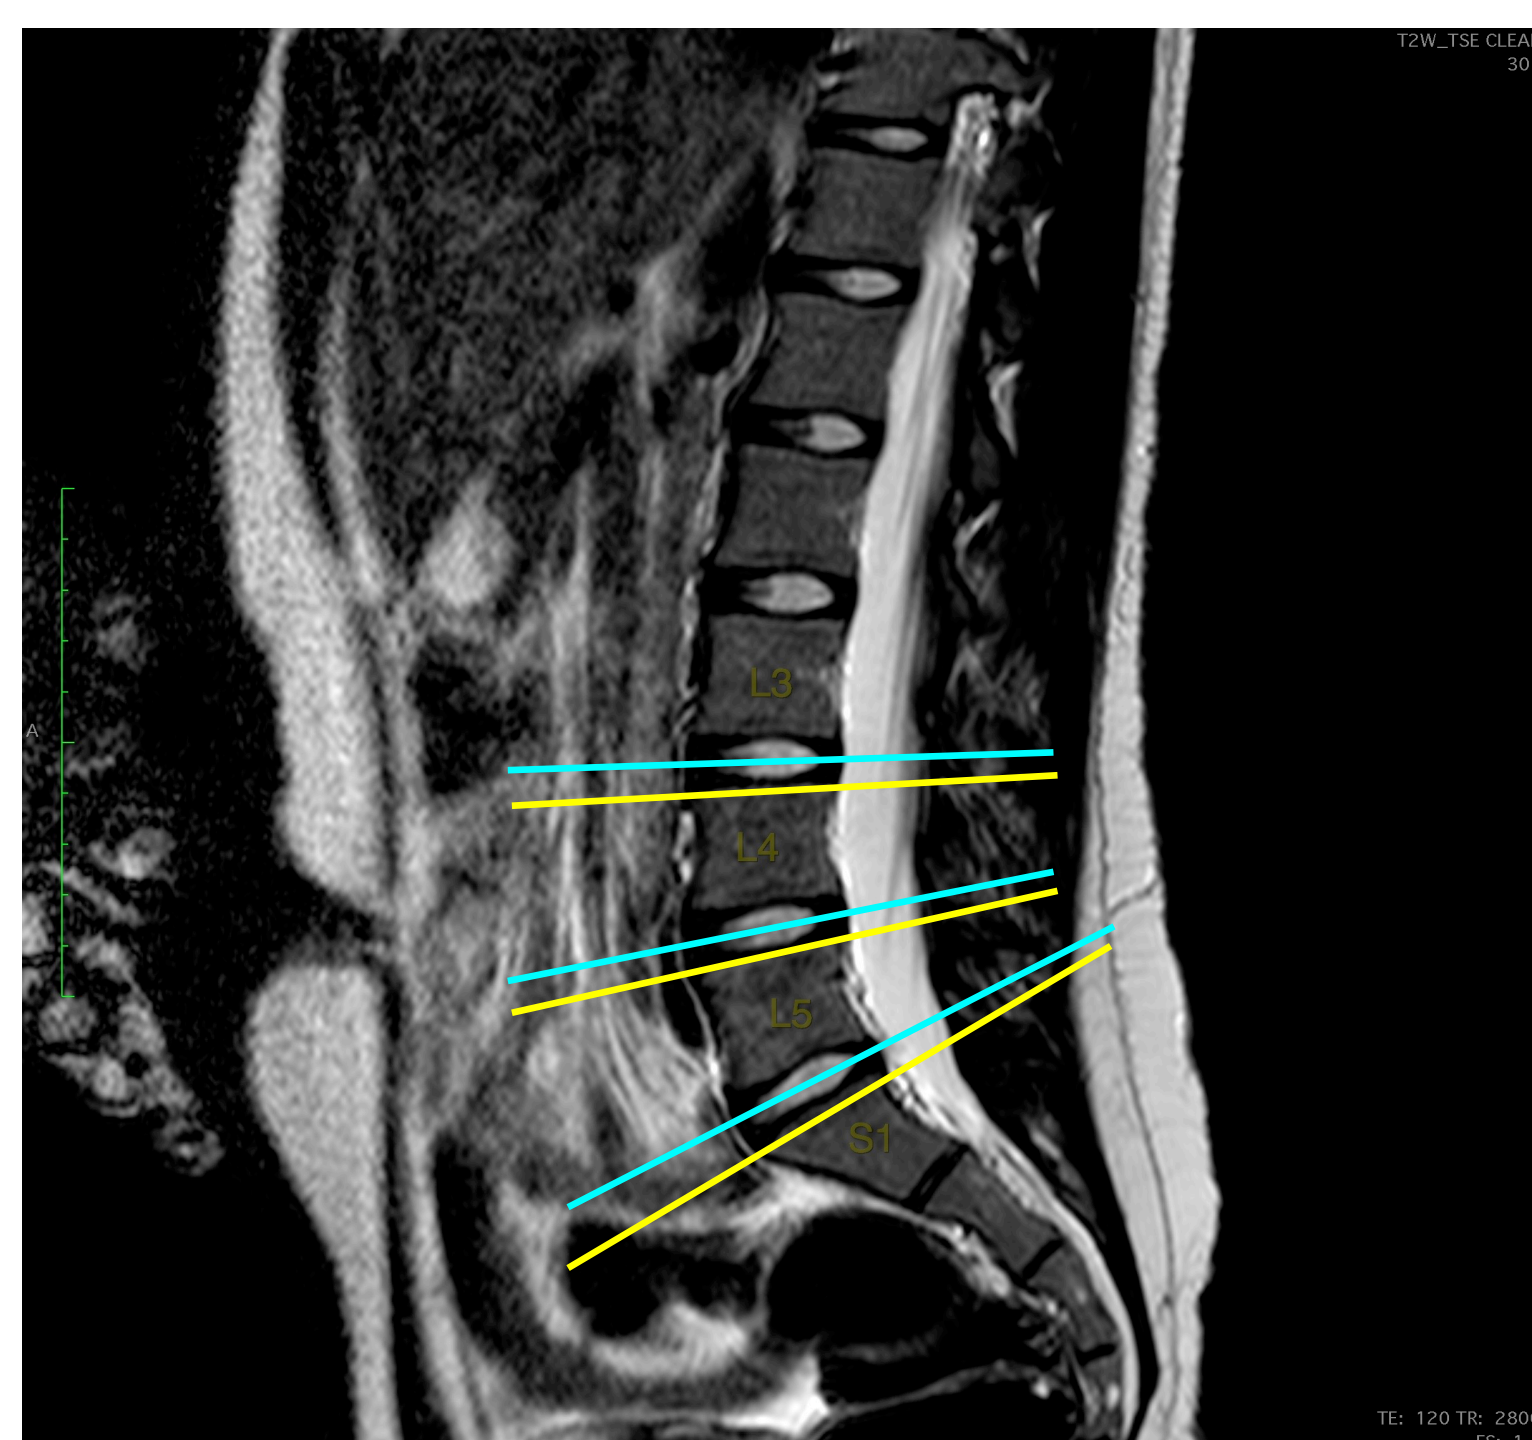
T2-weighted MRI sagittal view of vertebrae. Axial slices were taken at the mid-disc level of L3/4, L4/5, L5/S1 (blue) and at the corresponding inferior endplate level (yellow)
